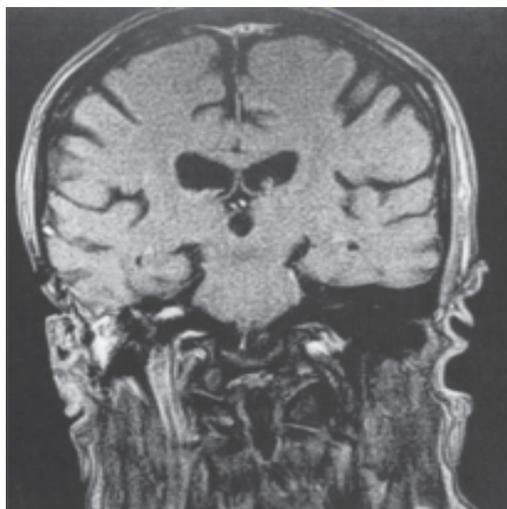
Follow up MRI in 2014 shows recurrence of the tumor.
